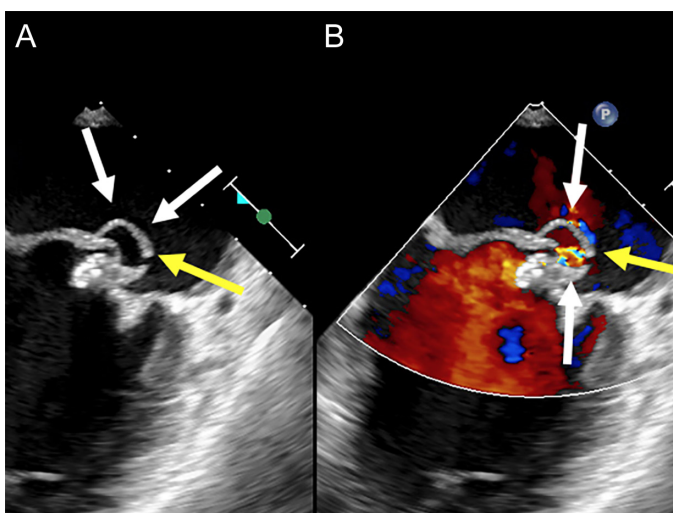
(A, B) Transesophageal echocardiography middle esophageal bicommissural view showing an aneurysm and rupture of anterior mitral valve middle scallop. White arrows indicating aneurysm of anterior mitral leaflet; yellow arrows indicating a hole on the aneurysmal wall.
